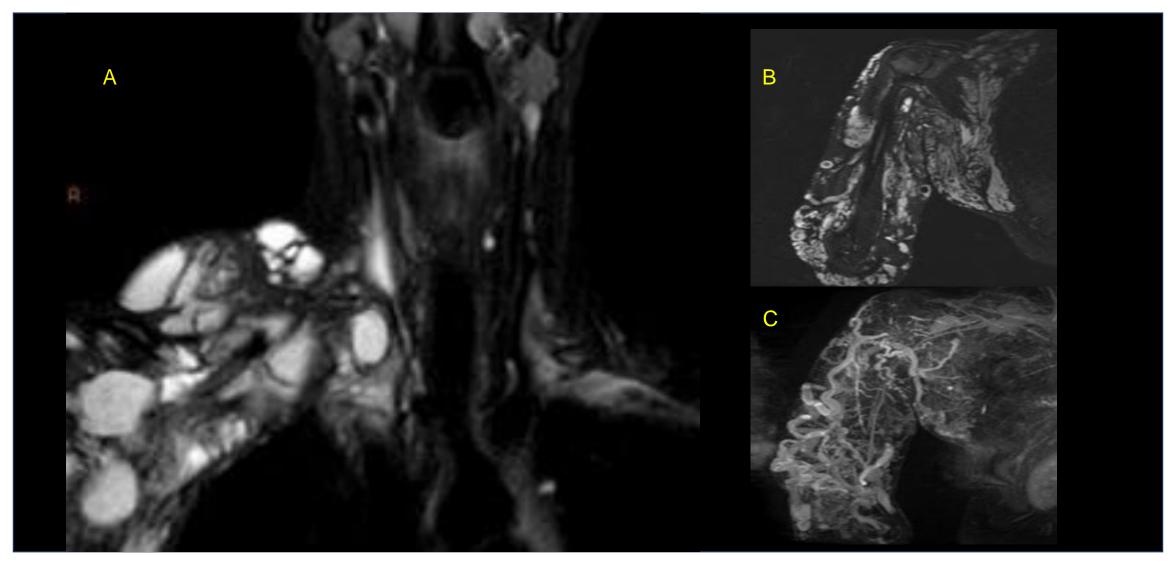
Upper Limb Arteriovenous Fistula. A: MRI, coronal STIR. B: MRI, coronal, arterial phase dynamic angiographic sequence. C: MRI, MIP reformation from arterial phase dynamic angiographic sequence. MRI shows abnormal direct communication between adjacent artery and vein characterized by early opacification of adjacent veins in the region of the arteriovenous fistula. Additionally, veins are dilated in response to high-flow arterialization.
